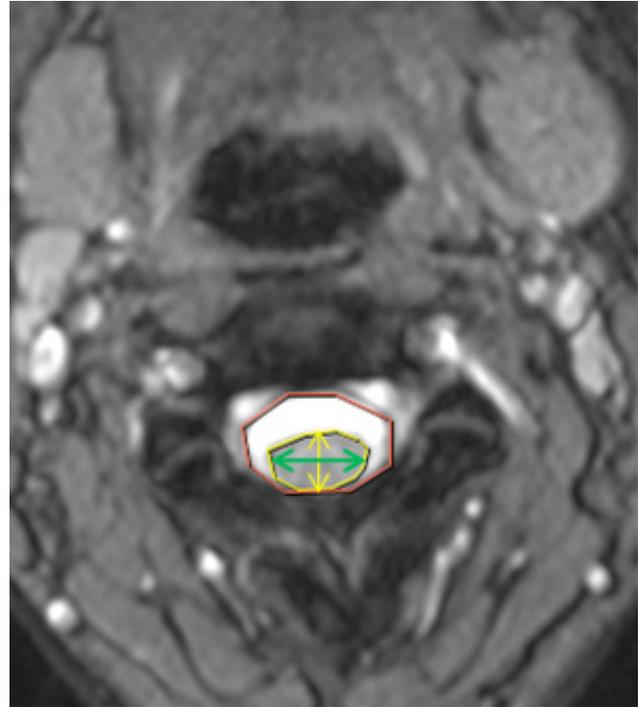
Axial section of T2-weighted MRI showing the measurements of antero-posterior diameter (yellow arrow) and transverse diameter (green arrow) of the cord, from which RAPT is calculated and cross-sectional area of the spinal canal (red line) and spinal cord (yellow line)
